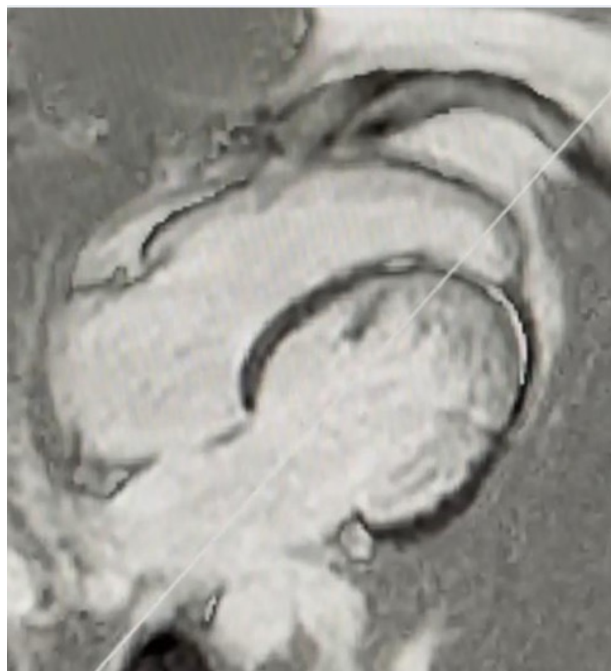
Cardiac magnetic resonance imaging with absence of late gadolinium enhancement and myocardial fibrosis.
